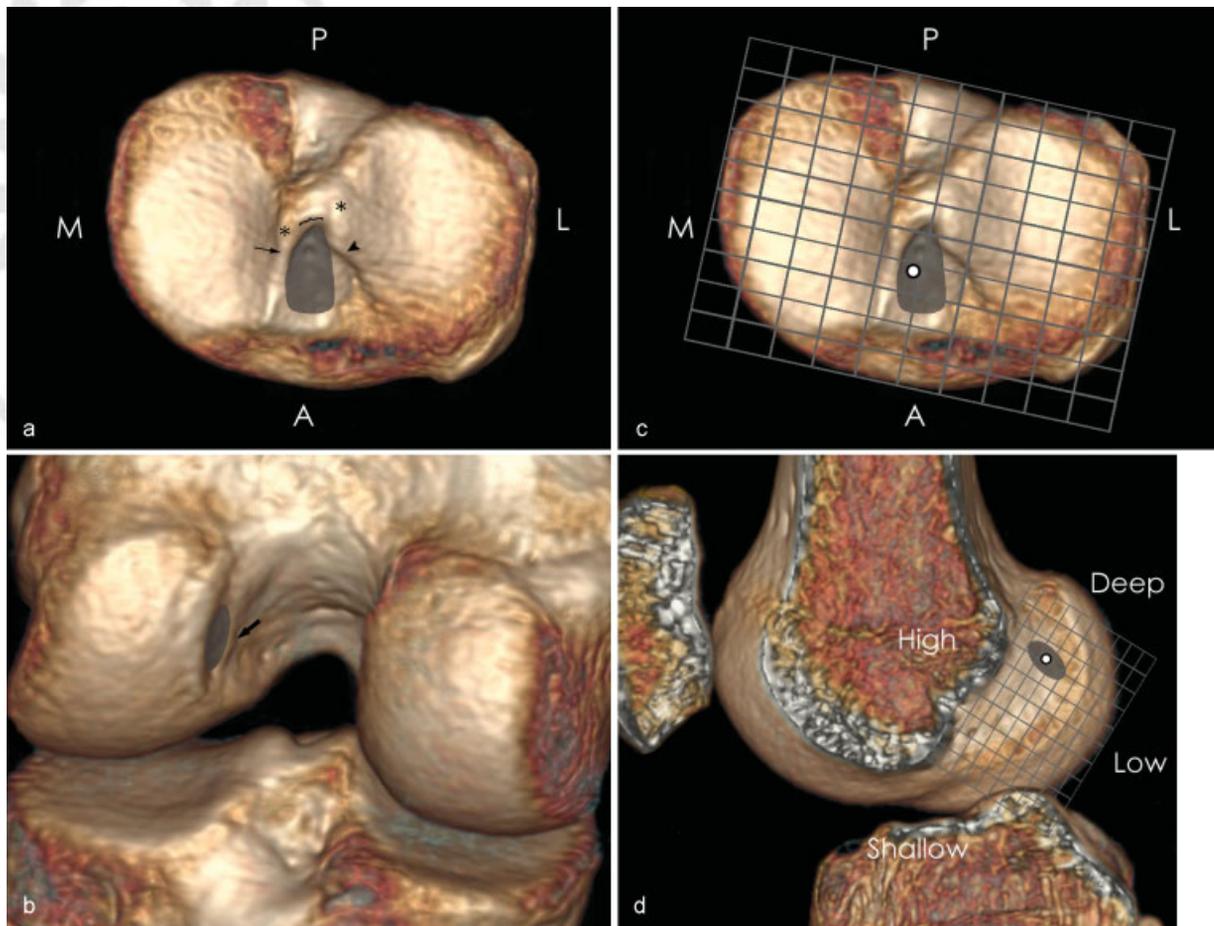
Computed tomography (CT) scan with volume-rendering reconstructions showing anterior cruciate ligament (ACL) attachments (gray area). (a) Superior view of the left tibia. ACL fibers extend up to the base of the tibial spine, but none of them insert on the tibial spine. Posterior fibers of the ACL are seen just anterior to a bony ridge that runs between the medial and lateral tibial intercondylar tubercles (asterisks), called the tibial ACL ridge (curly bracket). Medially, ACL fibers insert directly onto the anterior extension of the medial intercondylar tubercle, the medial intercondylar ridge (arrow), near the lateral border of the articular surface of the medial tibial plateau. There is no distinct bony lateral or anterior border of the ACL tibial footprint (lateral intercondylar ridge, arrowhead). (b) Posterior view of the left knee showing femoral ACL attachment. Note bony ridge at the anterior margin of the femoral footprint, called resident's ridge (arrow). Grid orientation system at the (c) tibial and (d) femoral ACL attachment. The reported optimal placement of bone tunnels is marked by a white dot in the footprint (see text for details).
